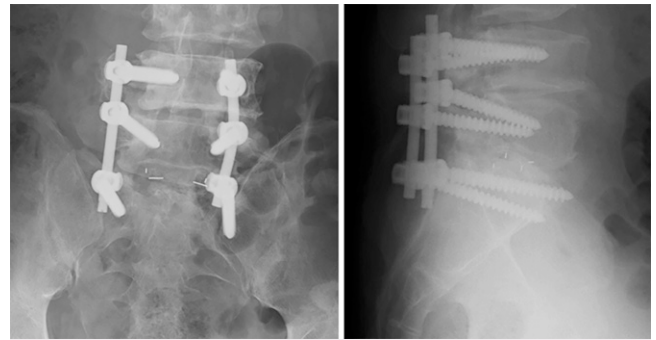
Postoperative radiographs. Left: Anteroposterior image showing the outwardly malpositioned bilateral S1 pedicle screws. The screws were inserted toward the outside of the S1 anterior foramen, especially on the left side. Right: Lateral image showing the tips of bilateral S1 pedicle screws perforating the anterior sacral cortex.
